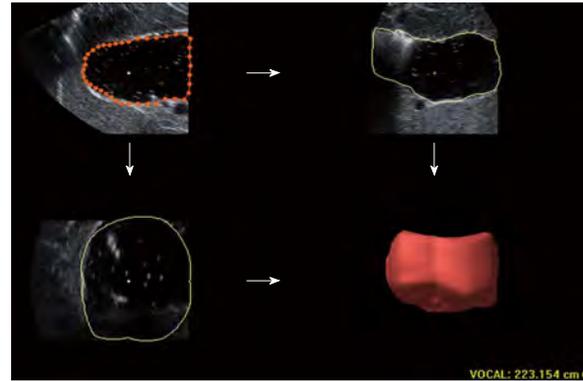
Three-dimensional ultrasound applied for measuring proximal gastric volume. The volume is measured similarly from the top inner margin of the fundus to 7 cm level inferiorly along the long axis of proximal stomach; six sections of the block from six 30° rotations are separately outlined along the echogenic interface in the upper left view. A reconstructive volume is displayed in the lower right view.
